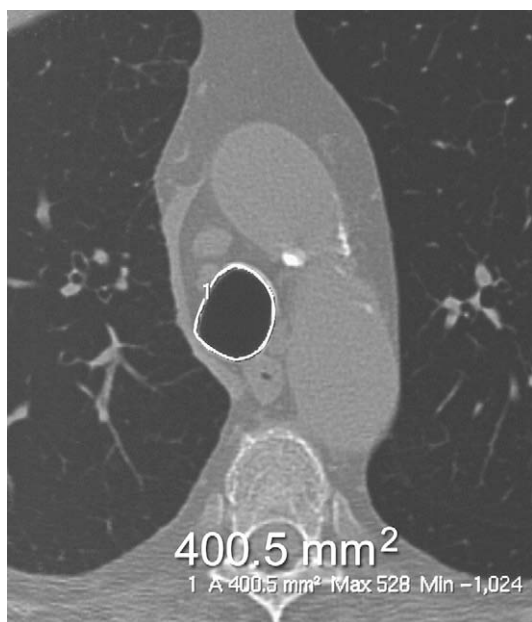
Example of electronic tracing method for measuring cross-sectional area of tracheal lumen at the level of the aortic arch. The tracing line has been electronically thickened to enhance visibility for photographic reproduction. (*Reprinted from Baroni RH, Feller-Kopman D, Nishino M, et al. Tracheobronchomalacia: comparison between end-expiratory and dynamic expiratory CT for evaluation of central airway collapse. Radiology 2005;235(2): 635–41; with permission.*)
